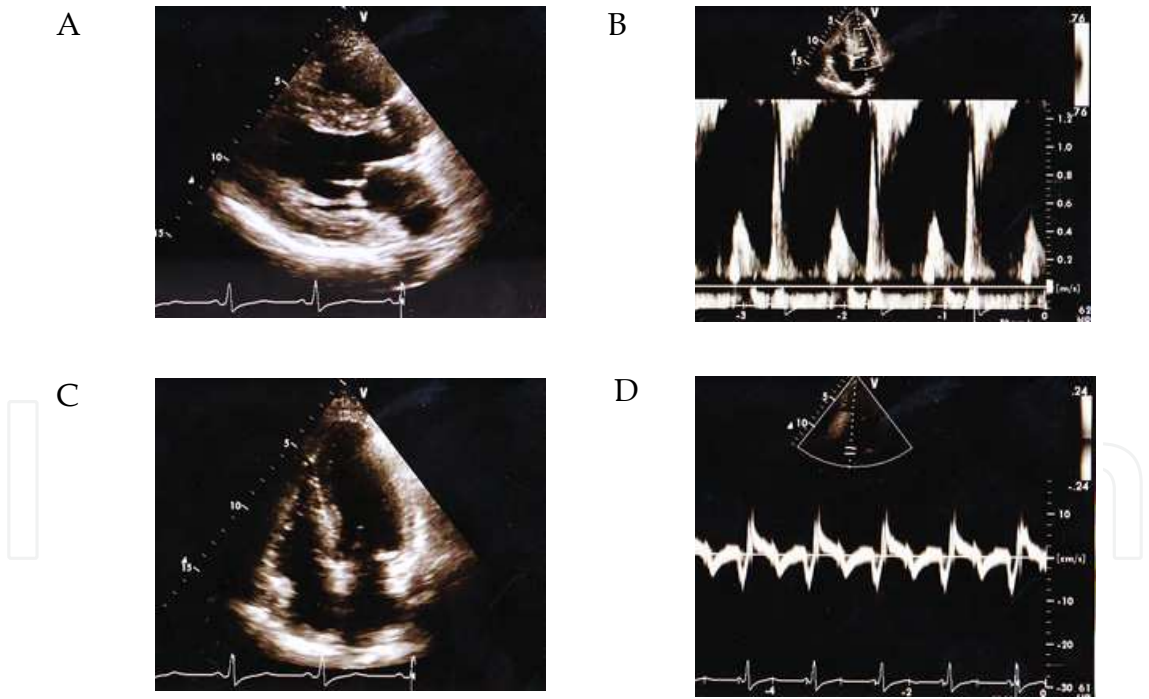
Abnormal relaxation pattern in LV inflow: Panel A shows long axis view. Panel B shows 4 chamber view. Panel C shows LV inflow. Panel D shows tissue Doppler imaging.
